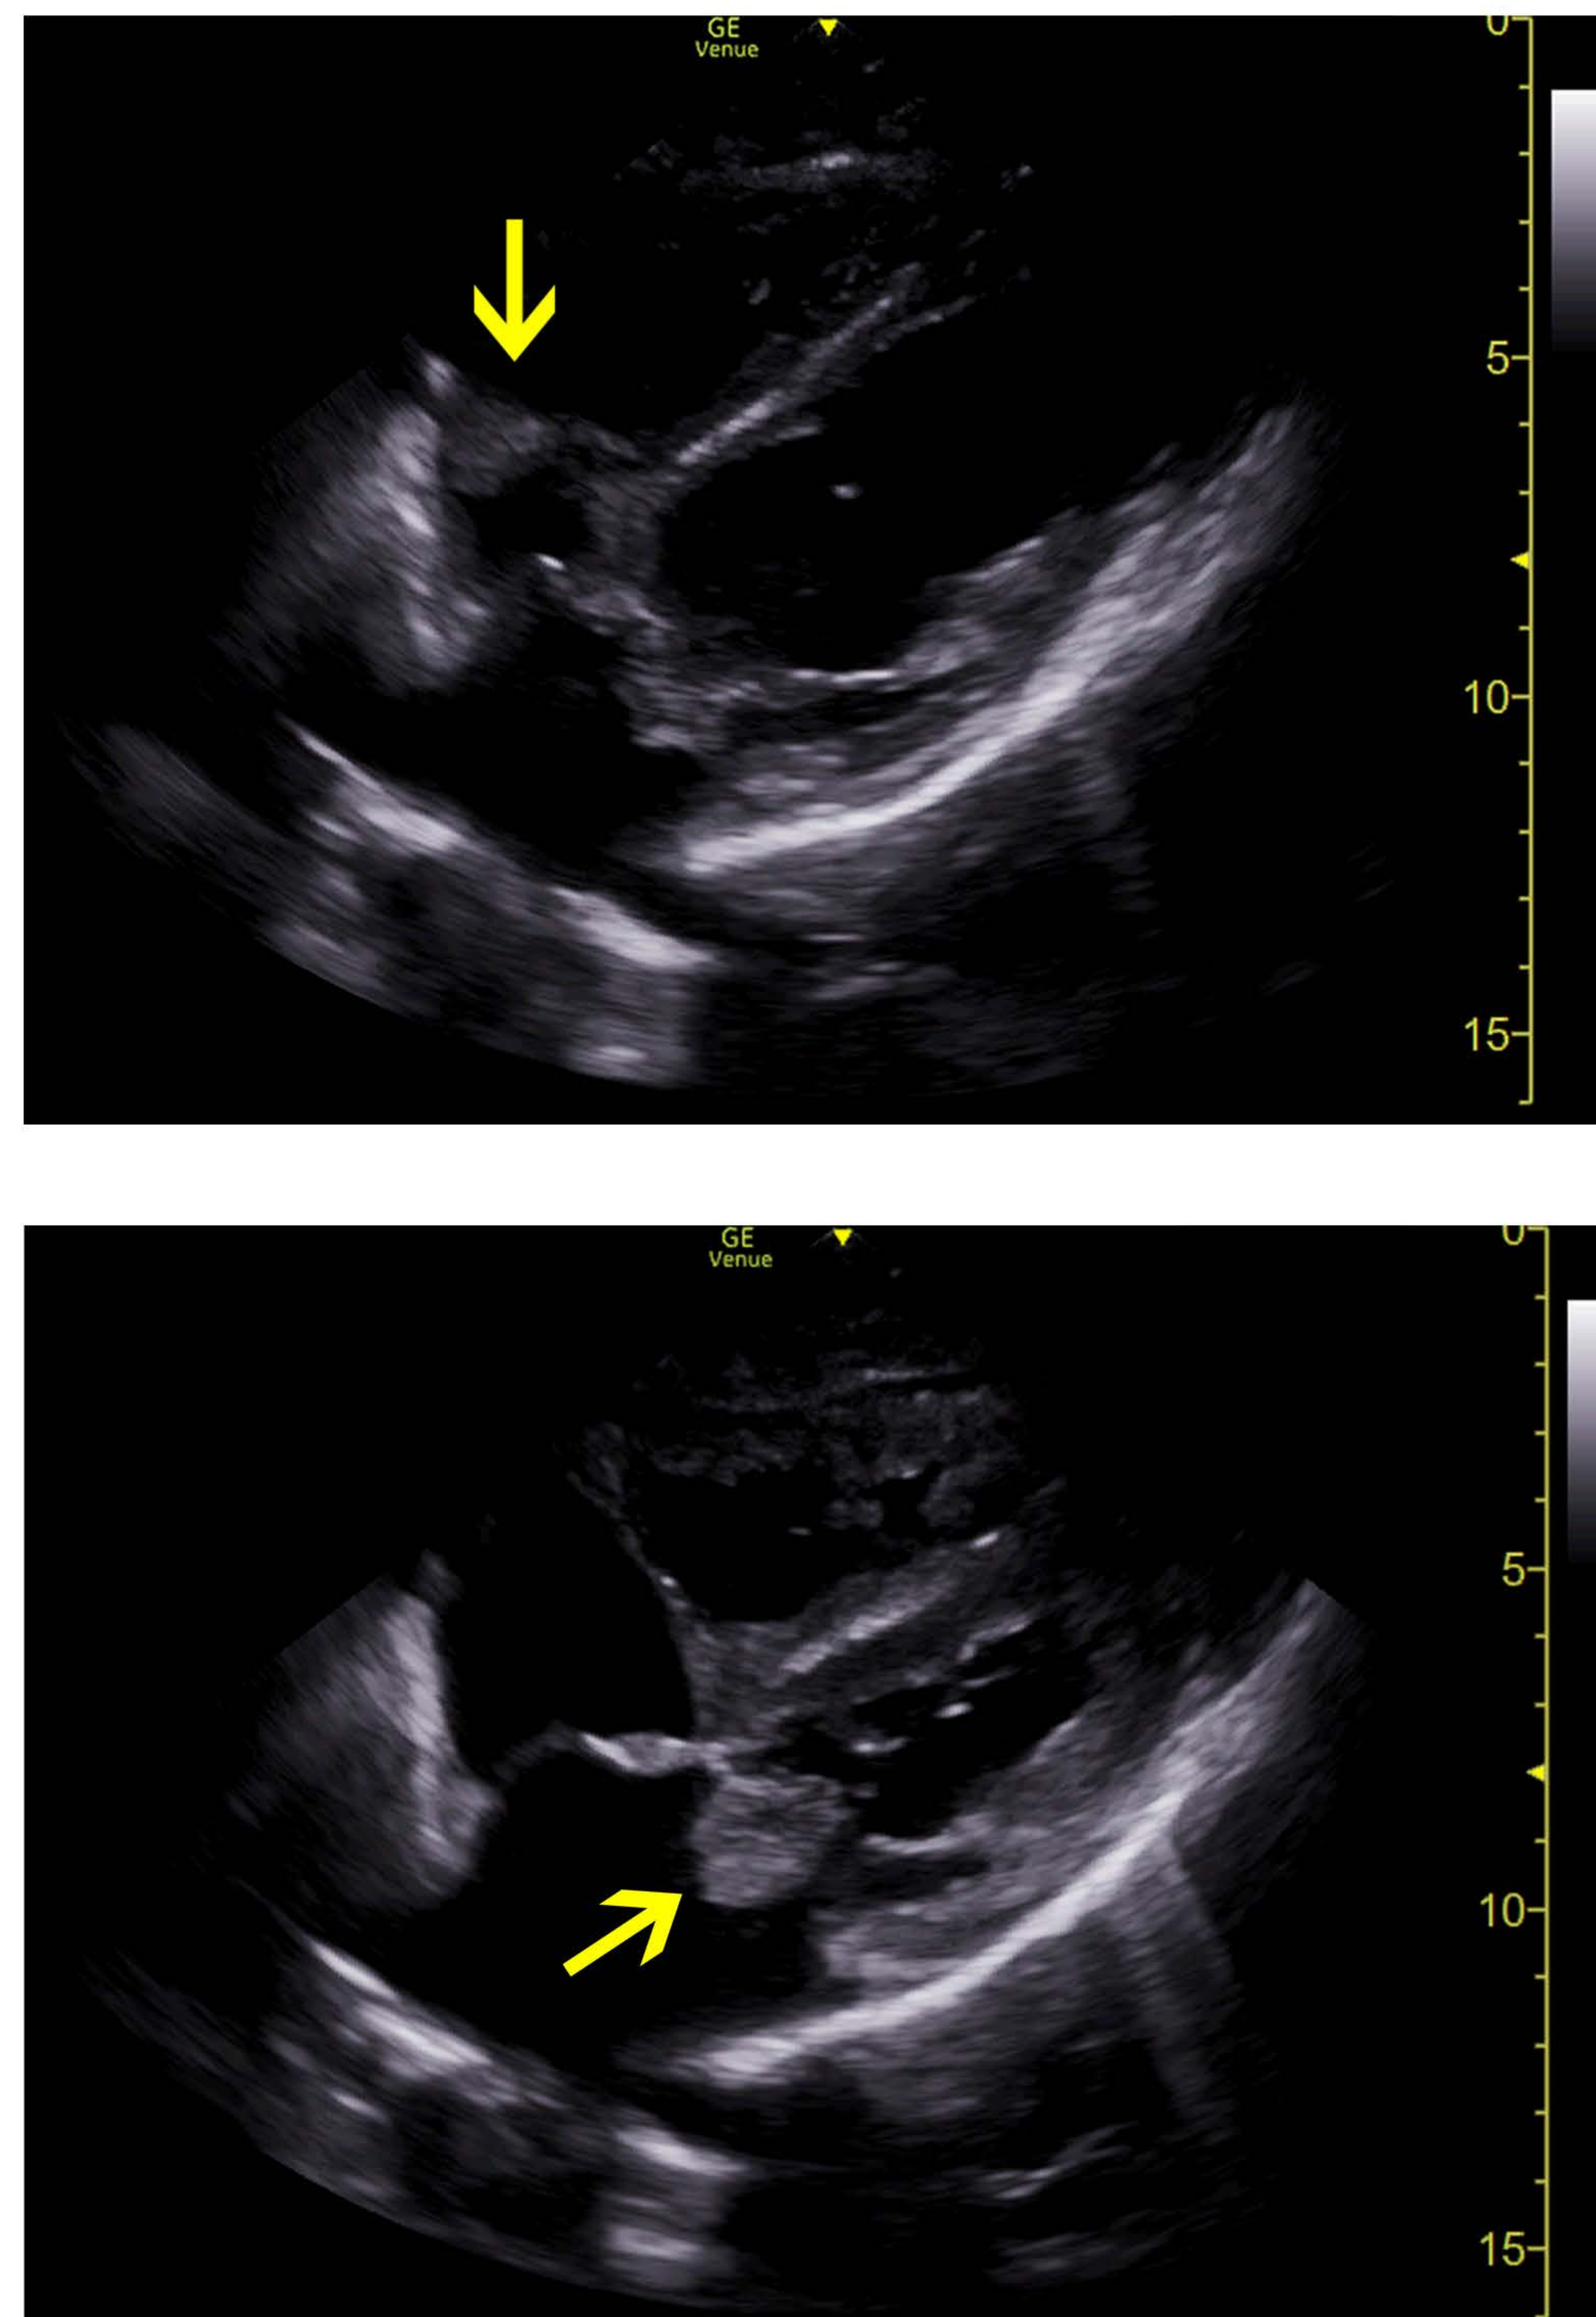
Point of care ultrasound showing vegetations on the tricuspid valve (left) and mitral valve (right).
